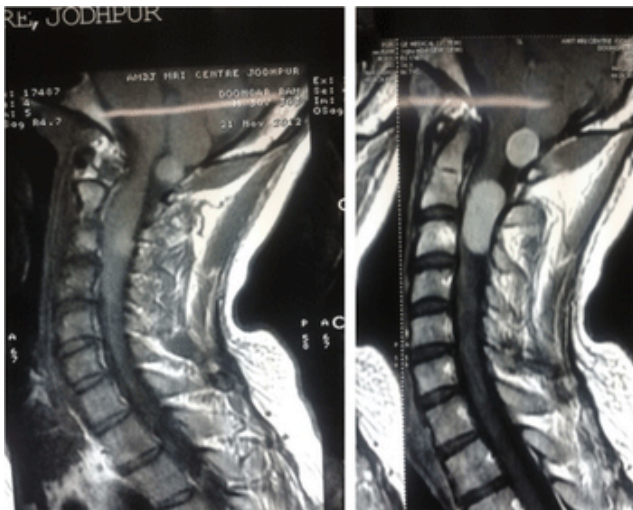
MRI of cervical spine, sagittal plane. MRI: Magnetic resonance imaging
